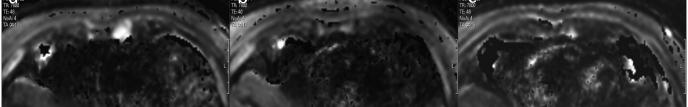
A) Baseline T2-MRI-sequences (a) and FUs (b, c) 3 and 6 months after SBRT. B) Baseline DW-MRI-sequences (a) and FUs (b, c) 3 and 6 months after SBRT.
